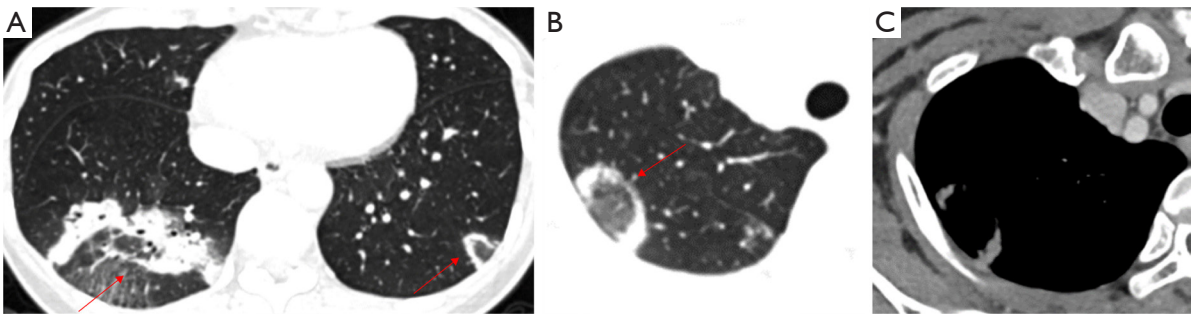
COPD. F, 48 y/o, a COPD patient with a cough for more than 20 days. (A-C) CECT showed multiple subpleural exudations, the reverse halo sign (as indicated by the arrows), and obvious uniform consolidation. COPD, chronic obstructive pulmonary disease; F, female; y/o, years old; CECT, contrast-enhanced computed tomography.
